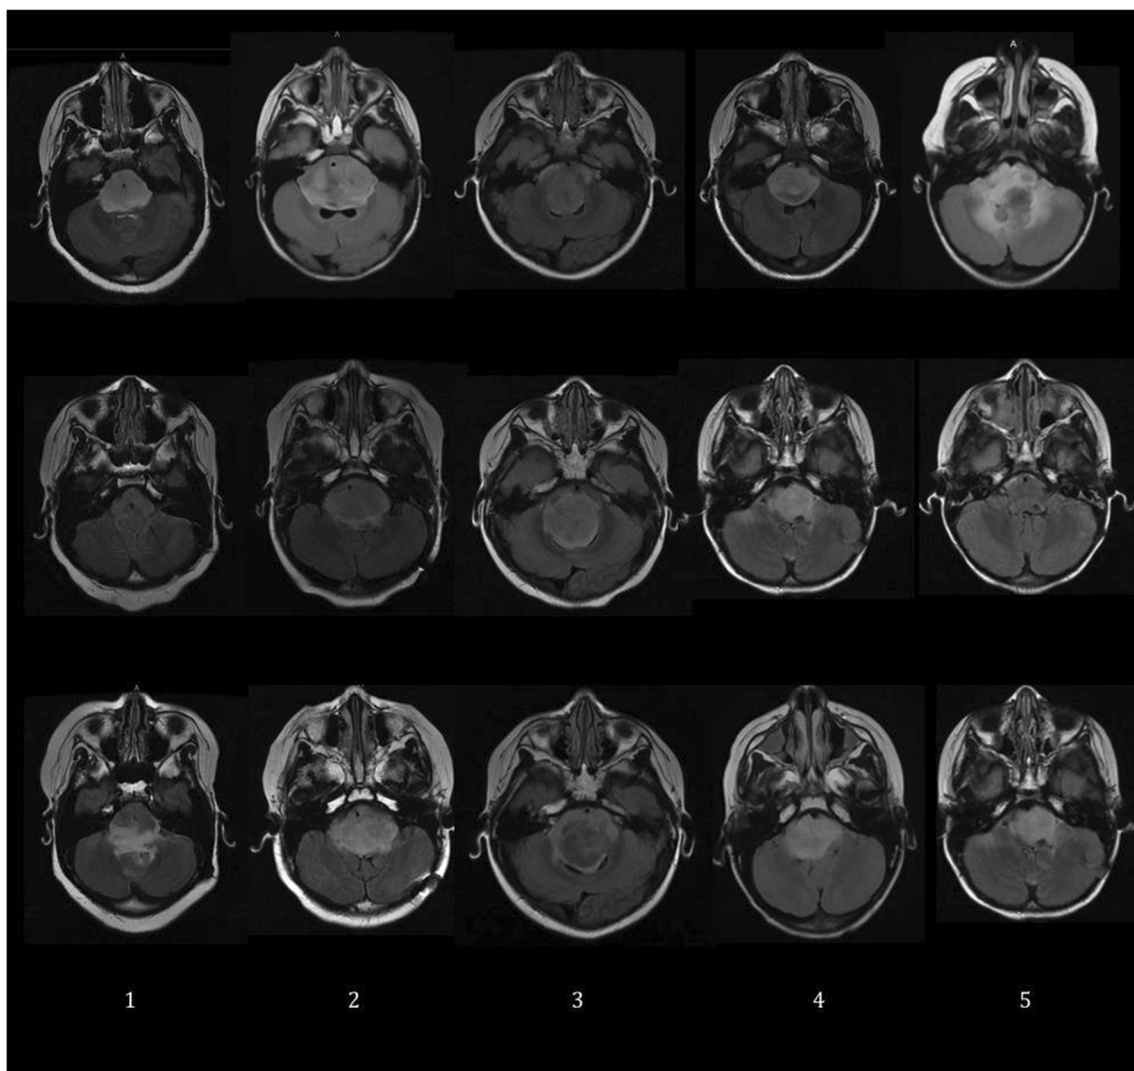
T2 FLAIR sequence MRI studies captured prior to first treatment (top row), after first radiation treatment completion (middle row), and prior to re-irradiation (bottom row) for each patient one through five
